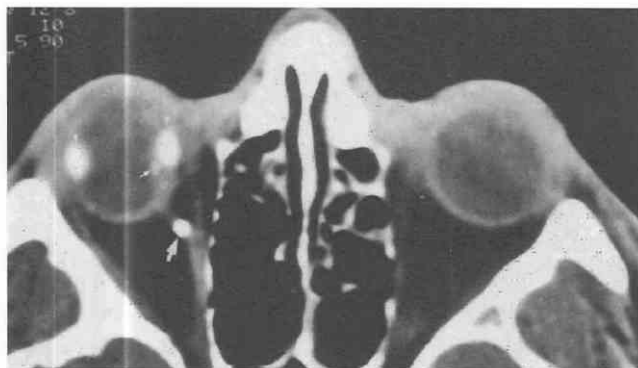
CT scan shows intraconal, metallic, foreign bodies just medial to the medial rectus (large arrow) and intraocular (small arrow). Scleral band in place right (arrowheads).
